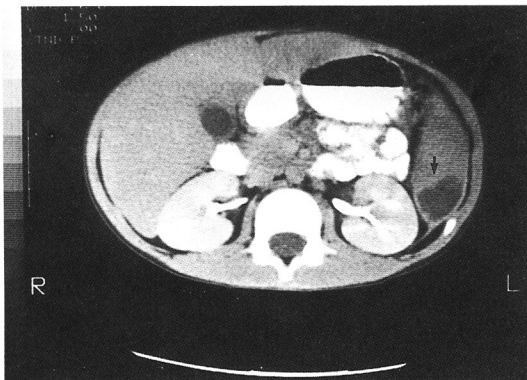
Abdominal CT scan showing non-enhancing, low density collections within an enlarged spleen.
